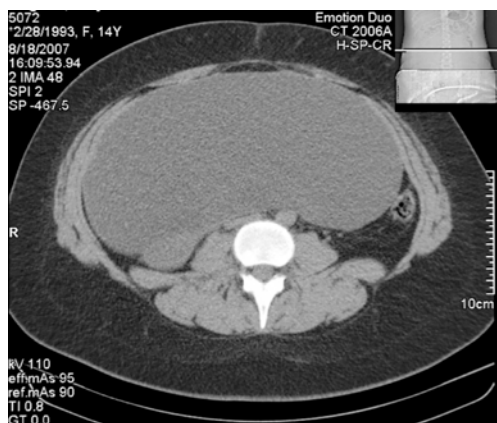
A computed tomography scan of the abdomen shows the hypodense cystic mass occupying the whole abdominal cavity
